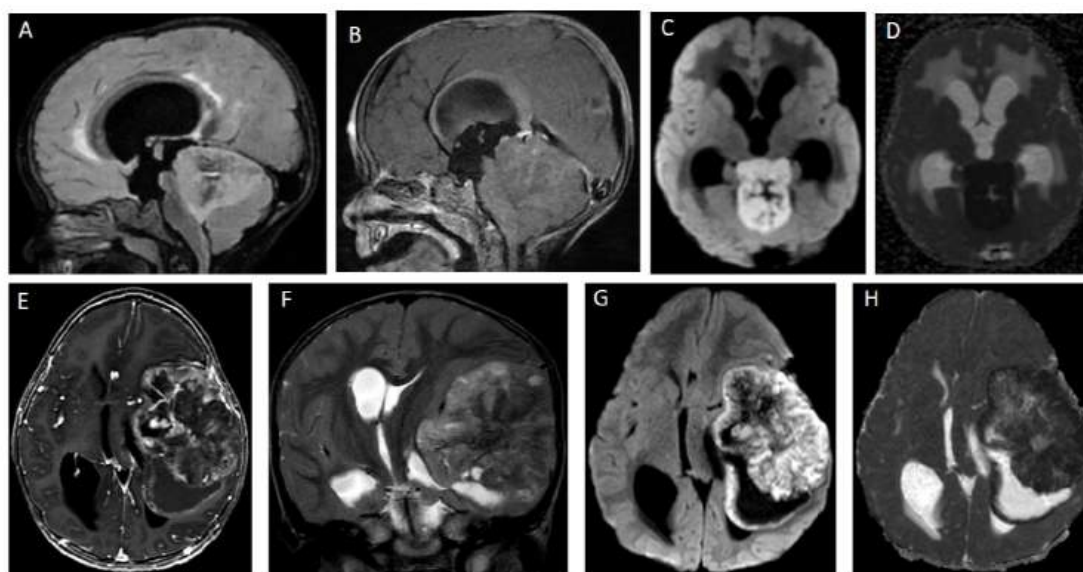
Typical MRI findings of ATRT
